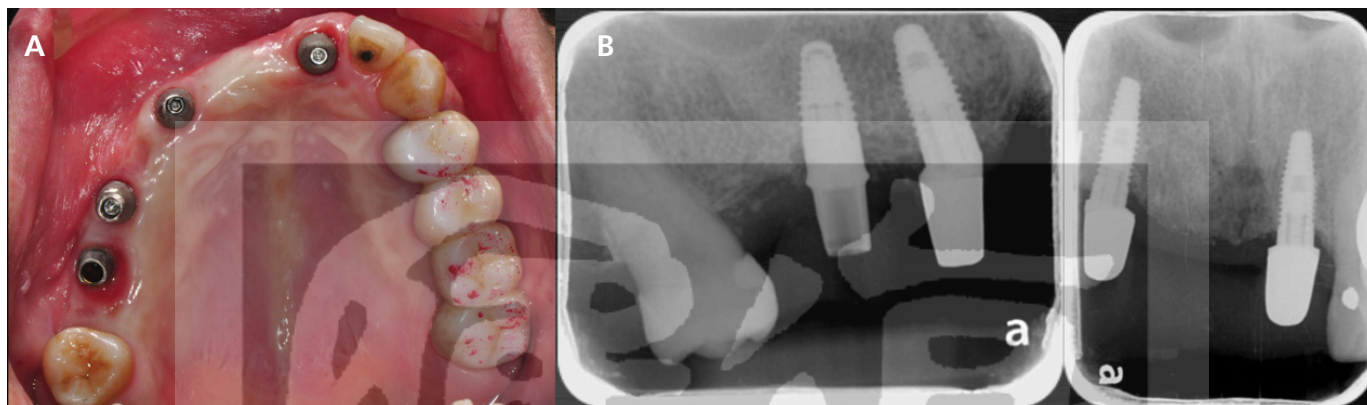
The 13,15,16,21 implant abutments. (a) occlusal intraoral view; (b) periapical film
